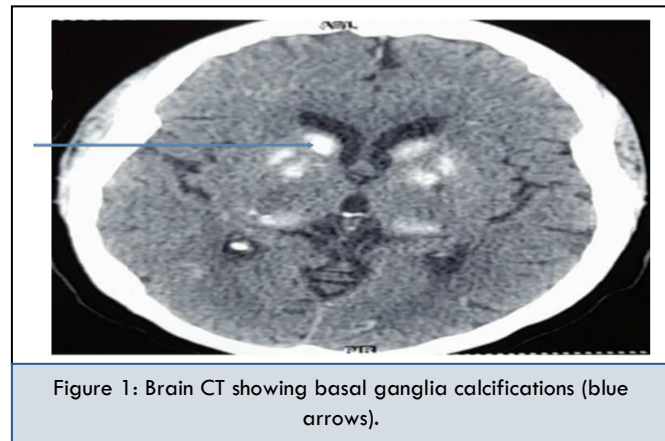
Brain CT showing basal ganglia calcifications (blue arrows).
